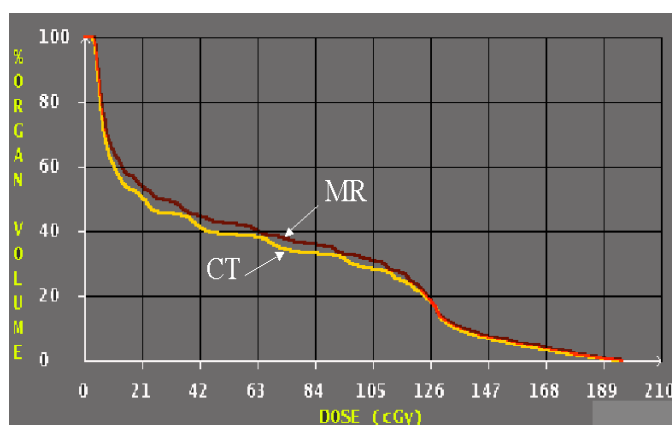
Comparison of DVHs for the rectum based on CT and MRI for patient 1. Since the DVH curves are ‘flat’ a small change in the rectal volume leads to a large change in the dose such as D35 but not in D17.
